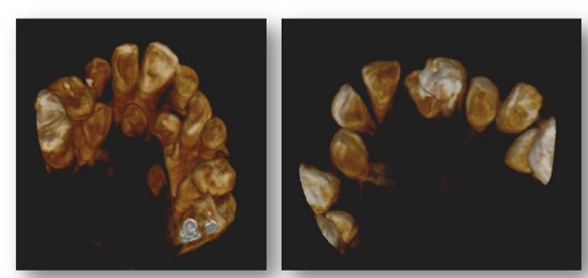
Pretreatment cone-beam computed tomography.
